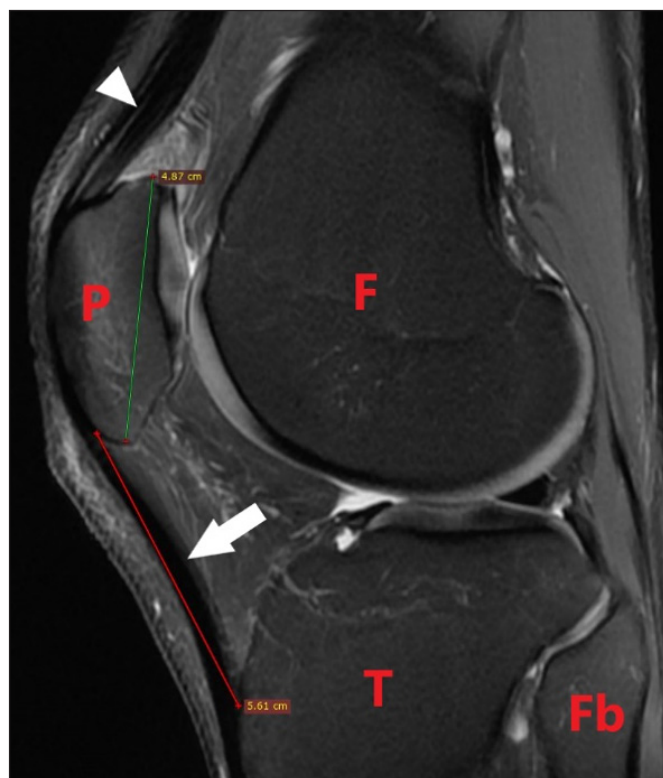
Patella and patellar tendon length measurements on sagittal MR image (fat-suppressed PD T2A). P: Patella, F: Femur, T: Tibia, Fb: Fibula, White arrowhead: quadriceps tendon, White arrow: patellar tendon
